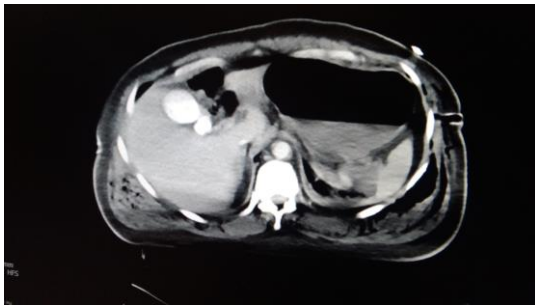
Abdomen CT scan.
